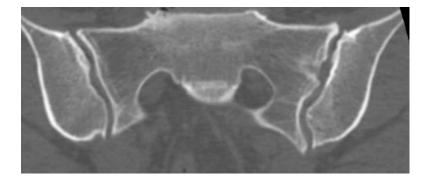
Coronal reformatted CT, on bone windows, of the sacroiliac joints
